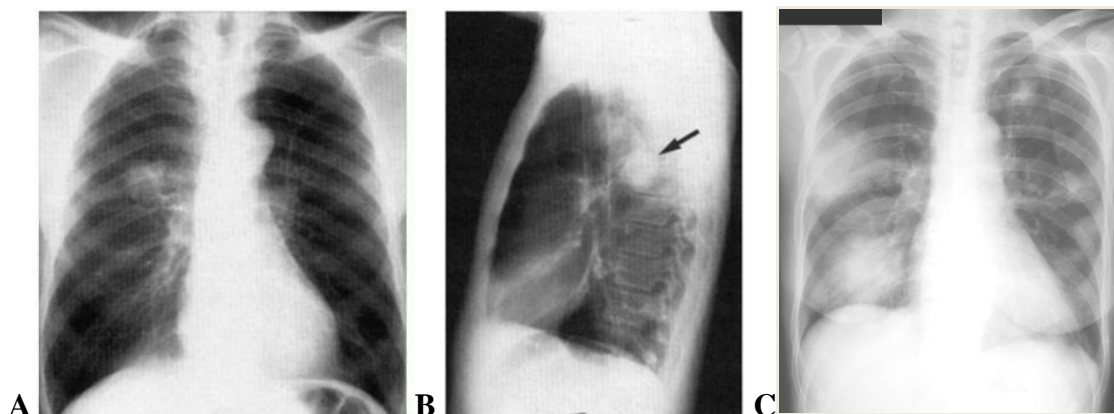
Round pneumonia. Well-defined round mass (arrow) in the right mid-lung in (A) posteroanterior and (B) lateral chest radiographs. (C) Legionnaire's disease. «Spherical» pneumonia with a nodular and focus areas of infiltrate. Frontal view of the radiograph chest shows a rounded soft-tissue density of both lung fields with mild bilateral hilar prominence
